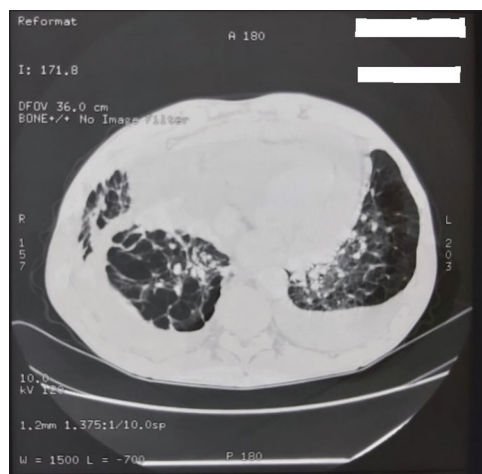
Chest computed tomography scan of the index case showing bilateral emphysematous bullae and minimal bilateral pleural effusion with no lung infiltrates
